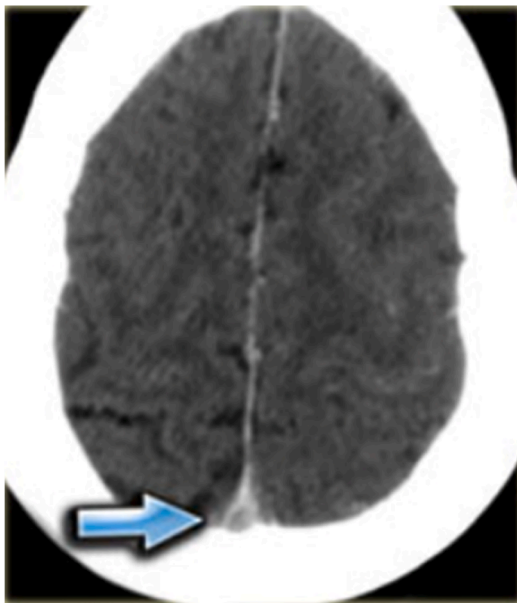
Empty delta sign: a finding seen on contrast-enhanced computed tomography consisting of a triangular area of enhancement with a relatively low attenuating center, which is the thrombosed sinus. (Cerebral Venous Sinus Thrombosis. Retrieved from: <https://radiologyassistant.nl/neuroradiology/sinus-thrombosis/cerebral-venous-thrombosis>.)
